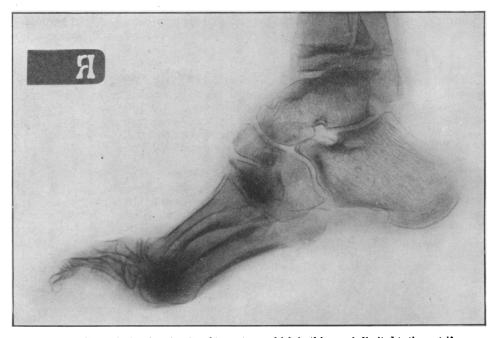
Radiograph showing the site of tarsectomy which in this case is limited to the cuneiform bones. The correction clinically was complete. See also fig. 4.
